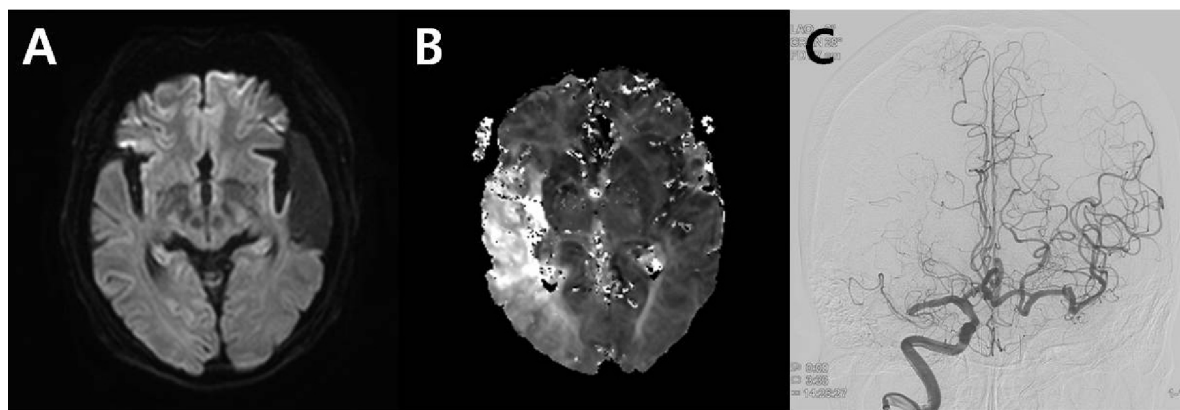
(A) Diffusion-weighted image (DWI) that was obtained 4 h after the onset of symptoms shows no acute lesions, except for the preexisting multiple encephalomalacic brain lesion in the right temporal lobe. (B) Perfusion-weighted image (PWI) of magnetic resonance imaging (MRI) shows a severe diffuse perfusion deficit at the right middle cerebral artery (MCA) territory and diffusion-perfusion mismatch. (C) A cerebral angiogram showing the occlusion of the right MCA bifurcation and total occlusion of the left proximal cervical internal cerebral artery.
